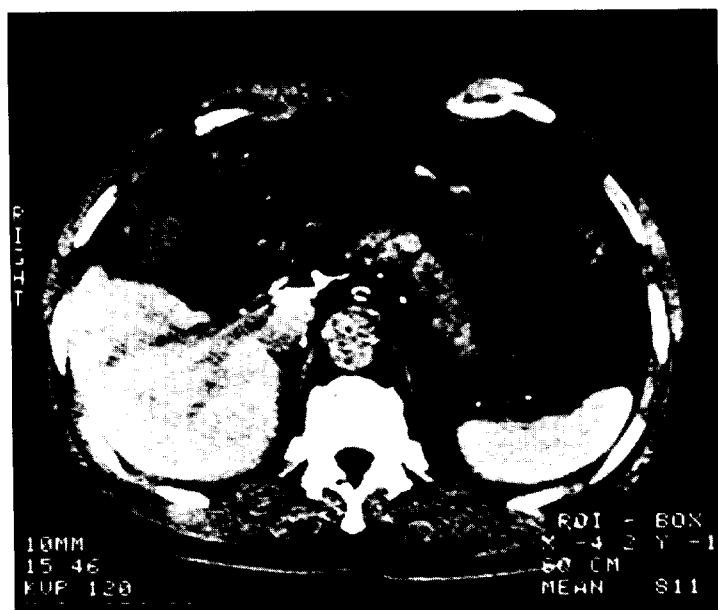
A typical CT scanning image of patient 1. The liver and the spleen showed high CT numbers.
